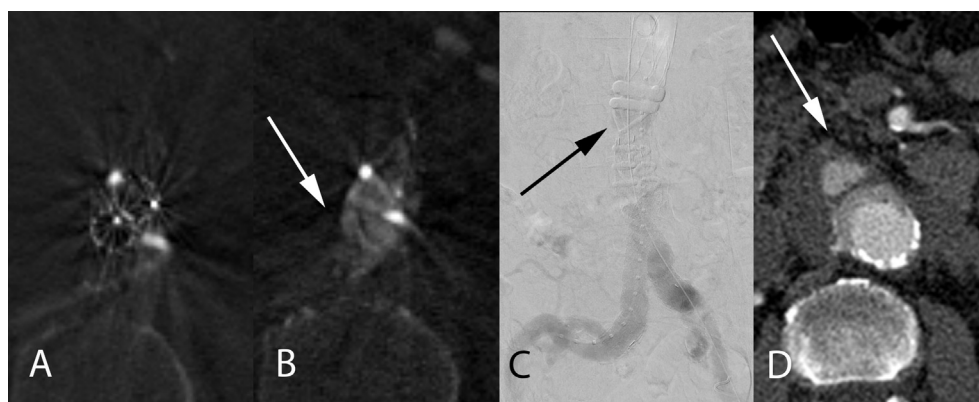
This figure shows the type 1 endoleak present during the implantation of an infrarenal stentgraft. (A) Pre-contrast cone beam computed tomography (CBCT) compared with (B) the contrast enhanced CBCT displaying a type 1 endoleak (arrow). (C) Completion angiography also reveals the proximal type 1 endoleak. (D) Follow up CT verifies the type 1 endoleak (arrow), which was left intentionally because of the need for a fenestrated cuff.
